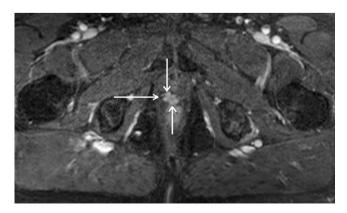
DCE-MRI of a patient with irregular contrast enhancing tissue (arrows) in the area of the vesicourethral anastomosis representing local recurence.
